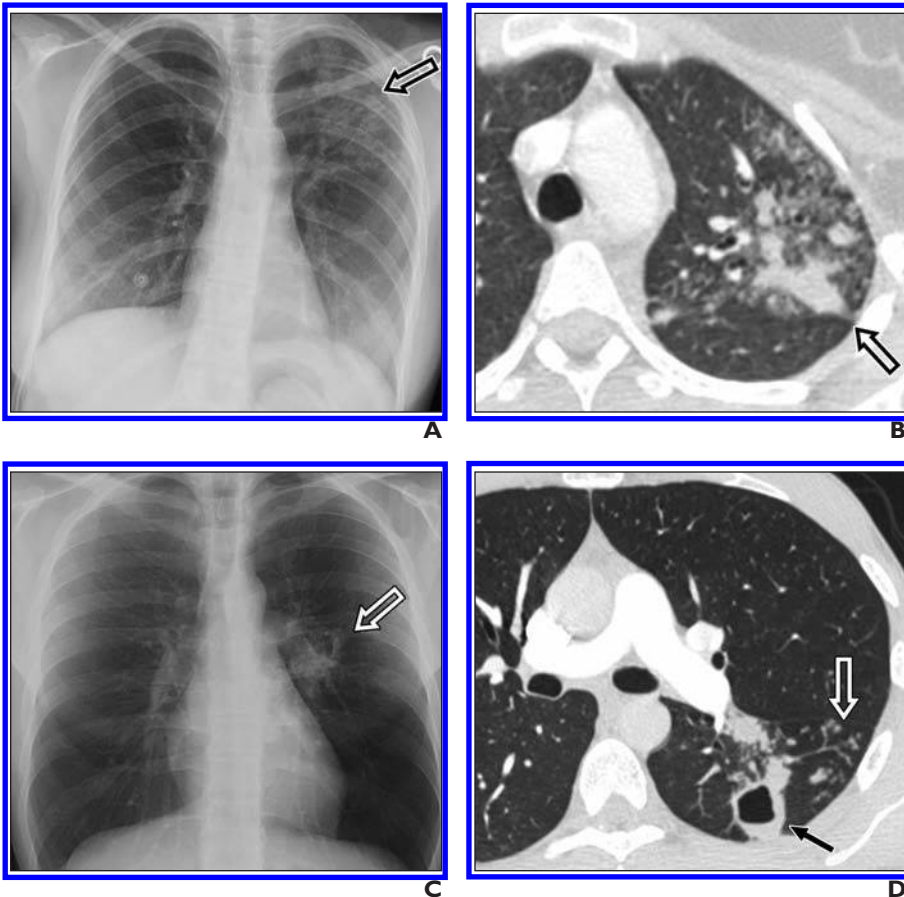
Recurrent tuberculosis. A and B, Posteroanterior chest radiograph (A) and transverse CT image (B) of chest show patchy heterogeneous consolidation in left upper lobe (*arrows*). C and D, Posteroanterior chest radiograph (C) shows opacity in perihilar region (*arrow*); transverse CT image of chest (D) confirms changes as cavitation (*solid arrow*) and also shows surrounding tree-in-bud pattern (*open arrow*).
